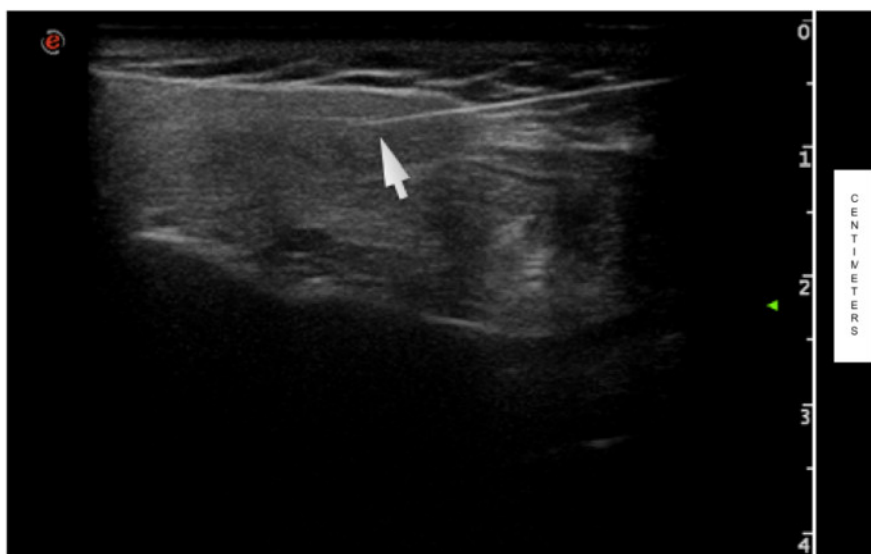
Ultrasound Injection of Parotid Gland. The arrow indicates the needle penetration, visible as a bright echoic line, within the parotid glandular tissue. Unit scale is expressed in cm. [Please click here to view a larger version of this figure.](#)
